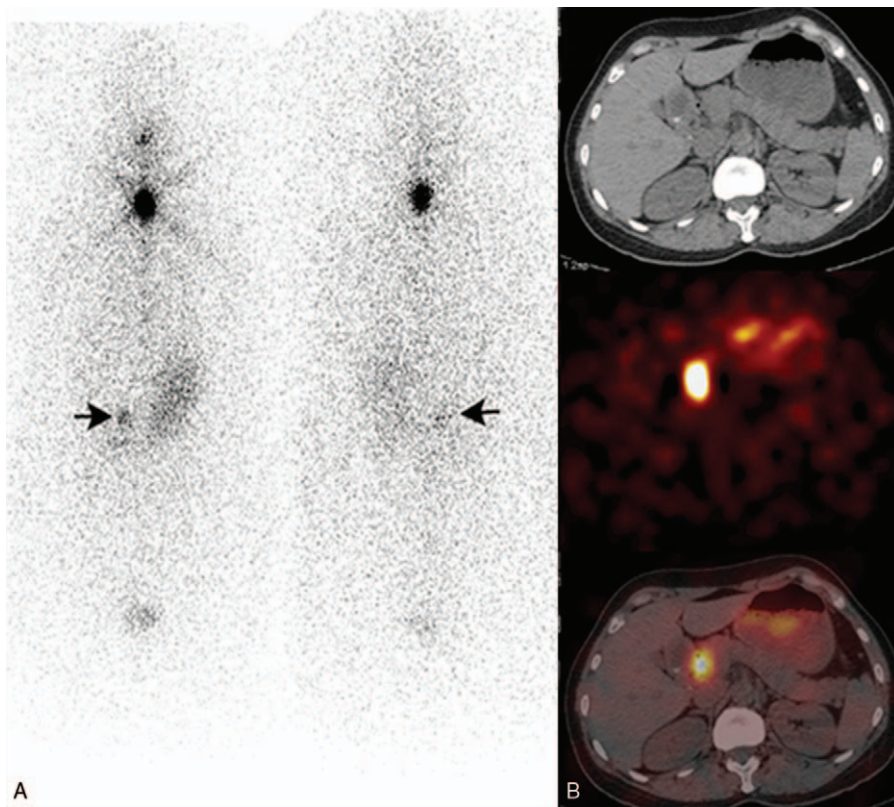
(A) whole body bone scintigraphy showed a focus of increased activity in right upper abdomen. (B) A SPECT/CT fusion imaging (top CT, middle SPECT, bottom fusion) found the focus of I-131 intensive uptake in the right upper abdomen localizing at the descending duodenum with a sacculated structure on CT. SPECT/CT = single-photon emission computed tomography/computed tomography.
